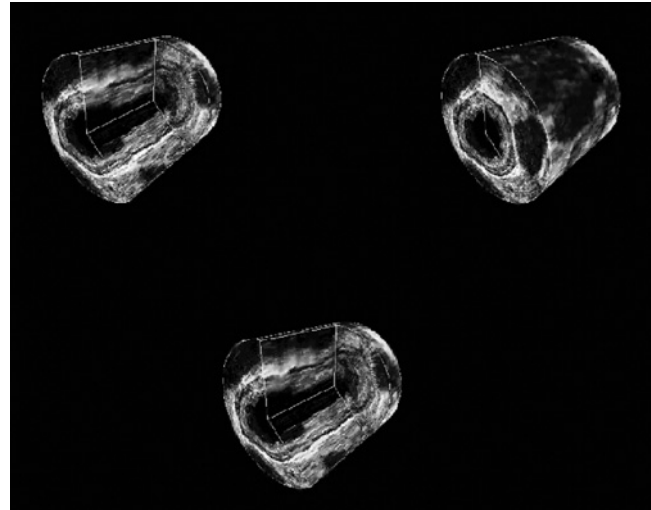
High-frequency ultrasound 3D imaging: reconstructed images.
